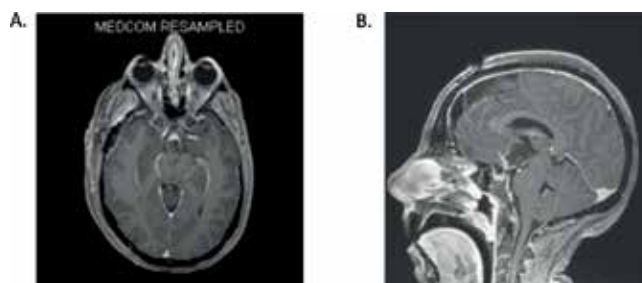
(A) Type IV supra-infundibular craniopharyngioma with intraventricular extension and (B) post-operative MRI demonstrates near-total resection of tumor with the opening of the lamina terminalis.
